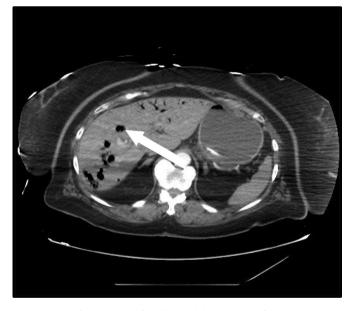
CT scan of the liver with large amount of air.
